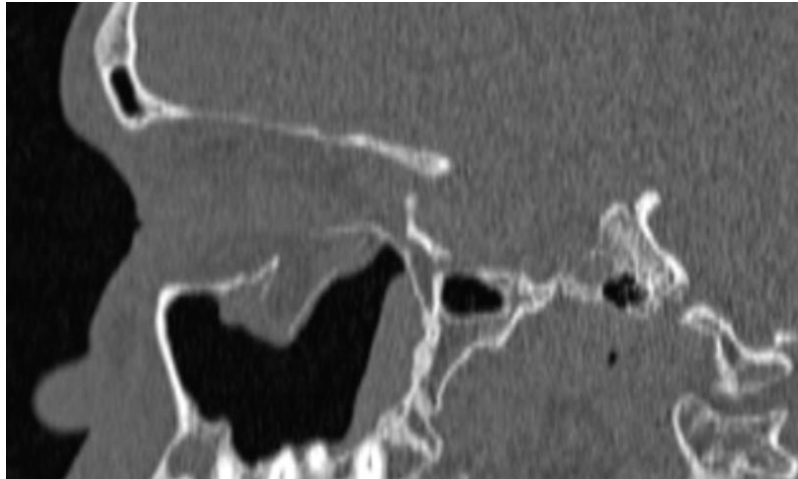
Sagittal section of CT scan showing orbital floor defect of middle and posterior third and herniation of soft tissue
